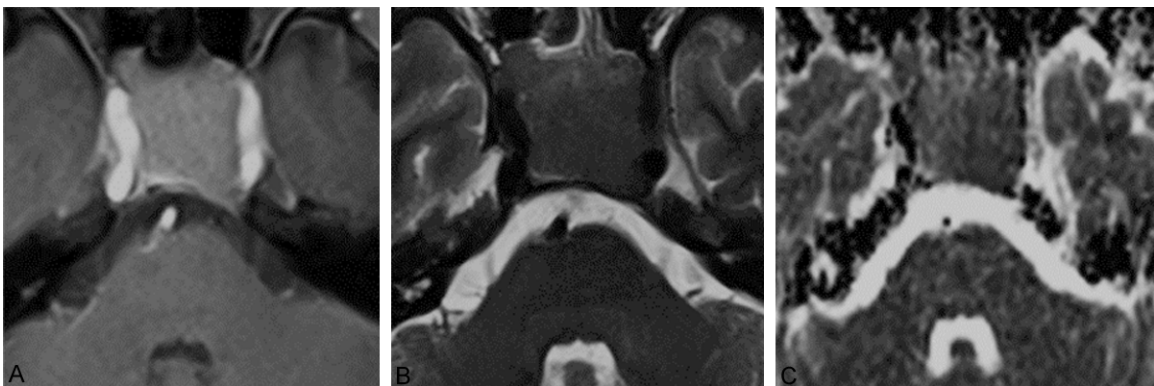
MRI images of 1 case of tough texture PA. A. Enhanced axial MRI image. B. Axial T₂WI image. $T_{2PA} = 0.260 \times 10^{-3} \text{ mm}^2/\text{sec}$, $T_{2ME} = 0.215 \times 10^{-3} \text{ mm}^2/\text{sec}$, $R_{T_2} = 1.21$. C. Axial ADC image. $ADC_{PA} = 0.732 \times 10^{-3} \text{ mm}^2/\text{sec}$, $ADC_{ME} = 0.697 \times 10^{-3} \text{ mm}^2/\text{sec}$, $R_{ADC} = 1.05$.
